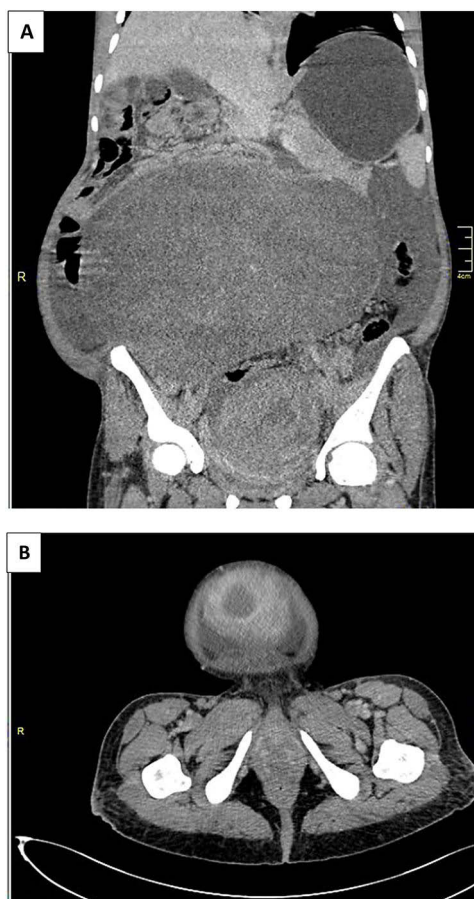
(A) Coronal CT showing a large heterogeneous uterine mass with necrosis and mass effect. (B) Axial CT demonstrating the pelvic extent of the lesion.
